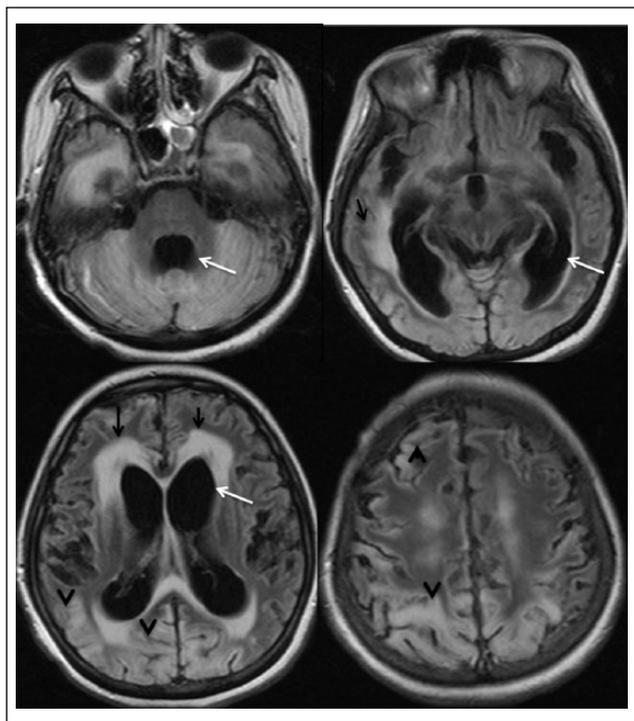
Magnetic resonance imaging scan of the patient 13 weeks after admission. Axial FLAIR images of the cerebral hemispheres demonstrate extensive FLAIR hyperintensities involving the cerebellum, temporal, parieto-occipital and right frontal regions (arrowheads) with generalised cerebral atrophy. The atrophy loss is more prominent in the left parieto-occipital lobe. All ventricles are dilated (white arrows) with evidence of periventricular hyperintensities (black arrows); the main differential is transependymal CSF seepage seen in communicating hydrocephalus, which is difficult to diagnose in the setting of brain atrophy.
